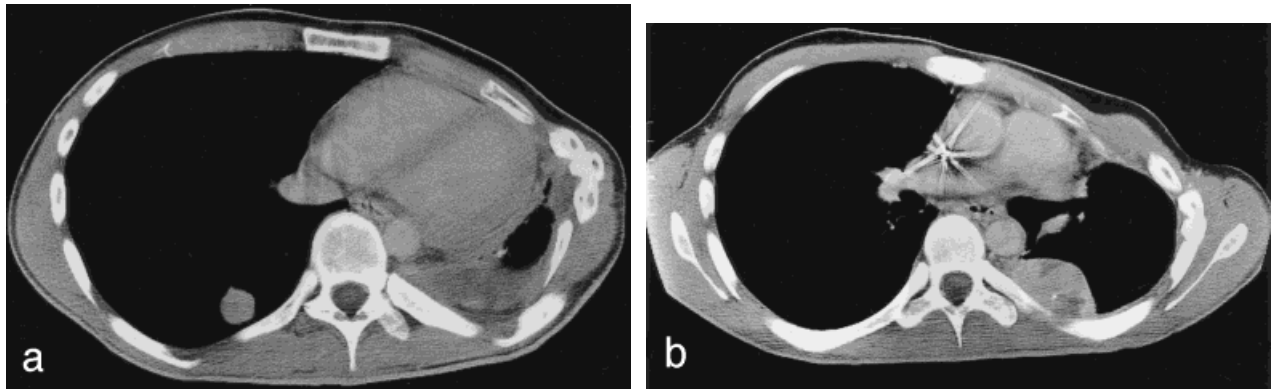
Computed tomography scans of the chest revealed a 2.5-cm right lower lobe mass with multiple pleural-based nodules along the posterior and left lateral pleural surfaces consistent with metastatic disease.
